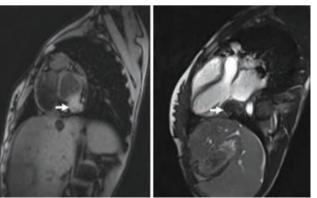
Cardiac magnetic resonance imaging showing complex chronic calcified pericardial haematoma of 30x30 mm.
